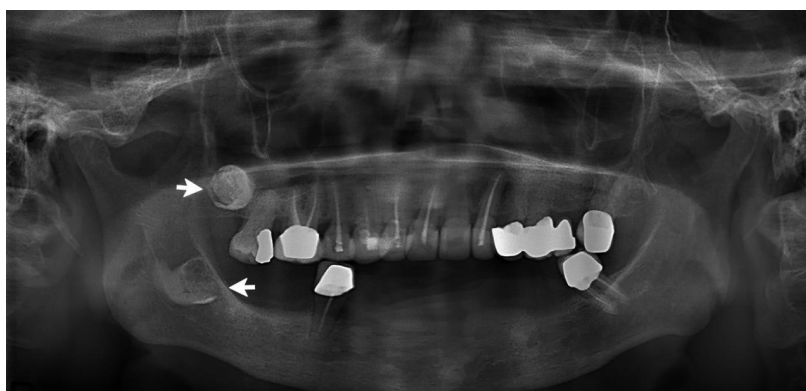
A panoramic radiograph of patient 1 reveals radiolucencies in the dental crown areas of the maxillary right and left third molars, which were impacted (arrows).
